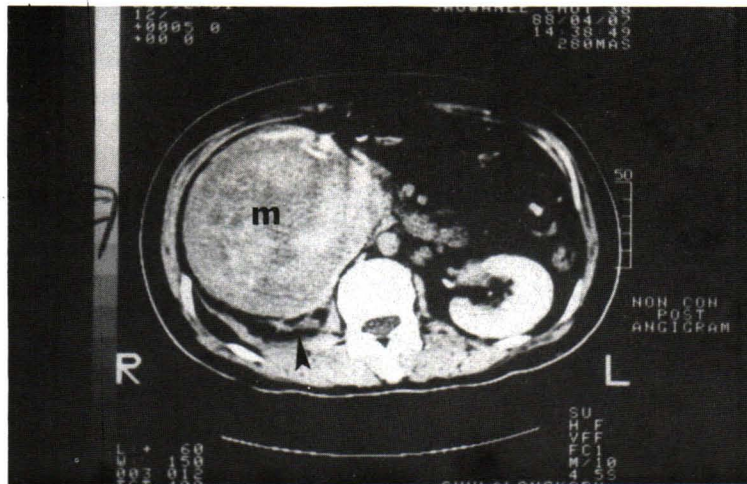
An enhanced axial CT scan shows an inhomogeneously enhanced mass with Gerota's fascia involvement (arrow head) in the right kidney (m).
